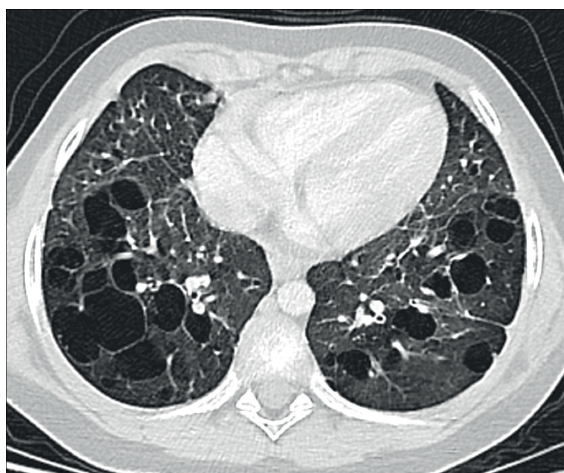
6-year-old boy with Langerhans cell histiocytosis. Axial computed tomography of the chest through lower lobes demonstrates numerous thin-walled lung cysts.
